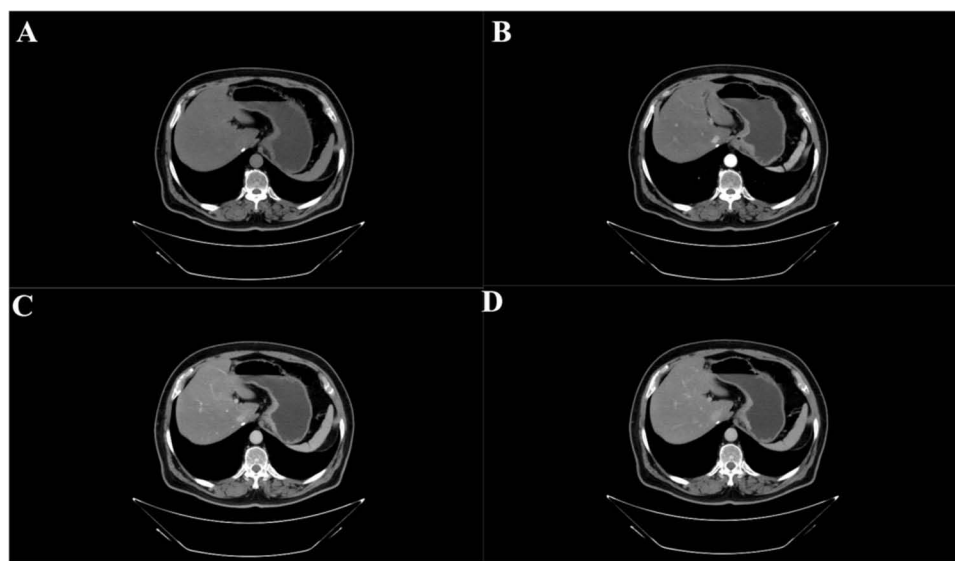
A 56-year-old man with PD-L1-negative. The gastric wall was thickened at the cardia, the CT values of the lesion on plain scan (A) and in the arterial phase (B), venous phase (C), delayed phase (D) were 27HU, 57HU, 76HU and 79HU, respectively. No enlarged lymph nodes, ascites and peritoneal metastasis were found in the abdominal cavity. EMVI was negative, and the CT stage was cT2N0.
